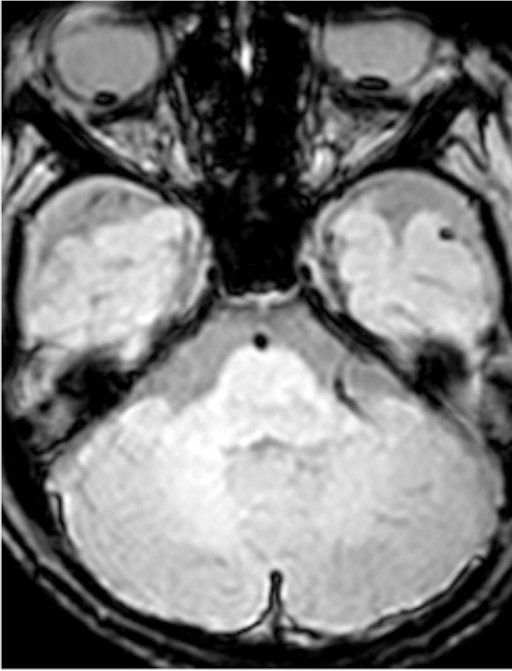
Four month old boy presented following an out of hospital arrest. CT demonstrated subdural haemorrhage. Axial susceptibility weighted sequences demonstrate low signal susceptibility artefact at the posterior aspects of both globes in keeping with retinal haemorrhages
